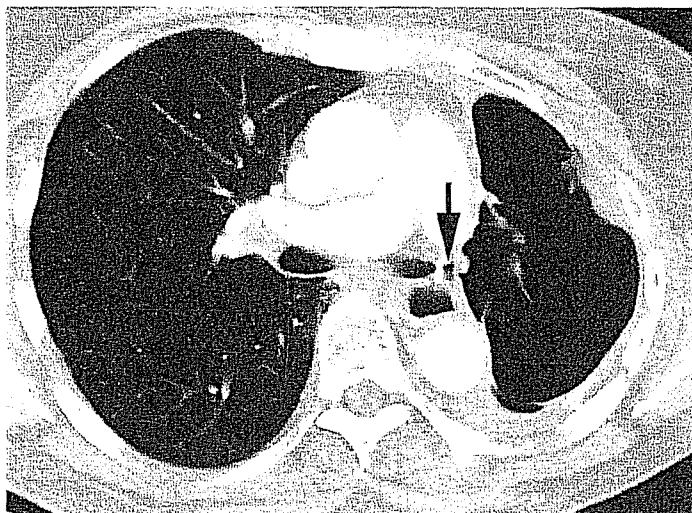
Central bronchopleural fistula in a 70-year-old woman following left pneumonectomy for a bronchial carcinoma. CT shows a large amount of air in the pneumonectomy space. Air leads from the bronchial stump to the pneumonectomy space (arrow).
